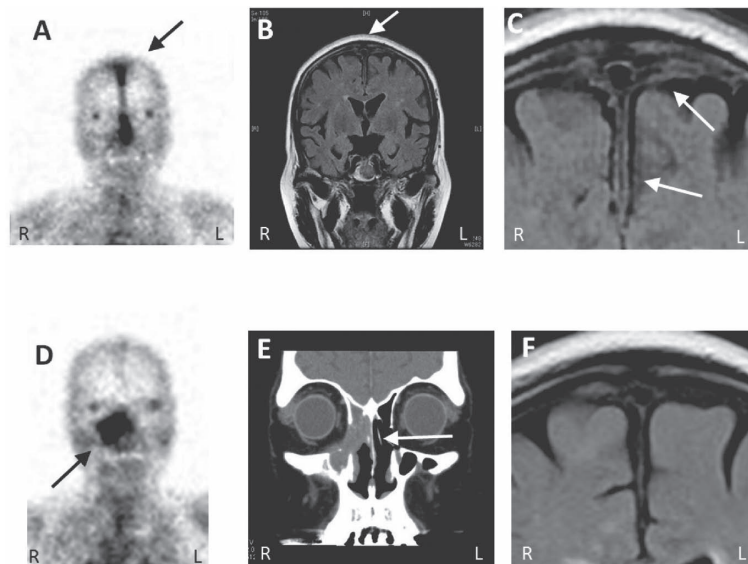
Imaging findings. A) Gallium scintigraphy showing hypertrophic pachymeningitis (HCP). Dense accumulation is seen at the falx cerebri (black arrow). B) Magnetic resonance imaging (MRI) showing HCP. A slightly swollen falx cerebri is evident (white arrow). C) Enlargement of the thickened region of dura mater is evident (white arrow). D) Ga scintigraphy indicating sinusitis (black arrow). E) Contrast-enhanced computed tomography showing right nasal sinus inflammation with osteolytic change (white arrow). F) Swelling in the falx cerebri is not apparent on MRI at the time of sinusitis.
